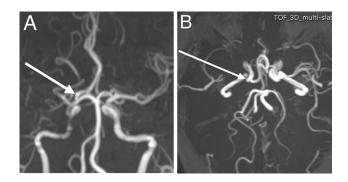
Occlusion of the right middle cerebral artery. (A and B) Loss of the right middle cerebral artery signal on 3D MRI-TOF.
